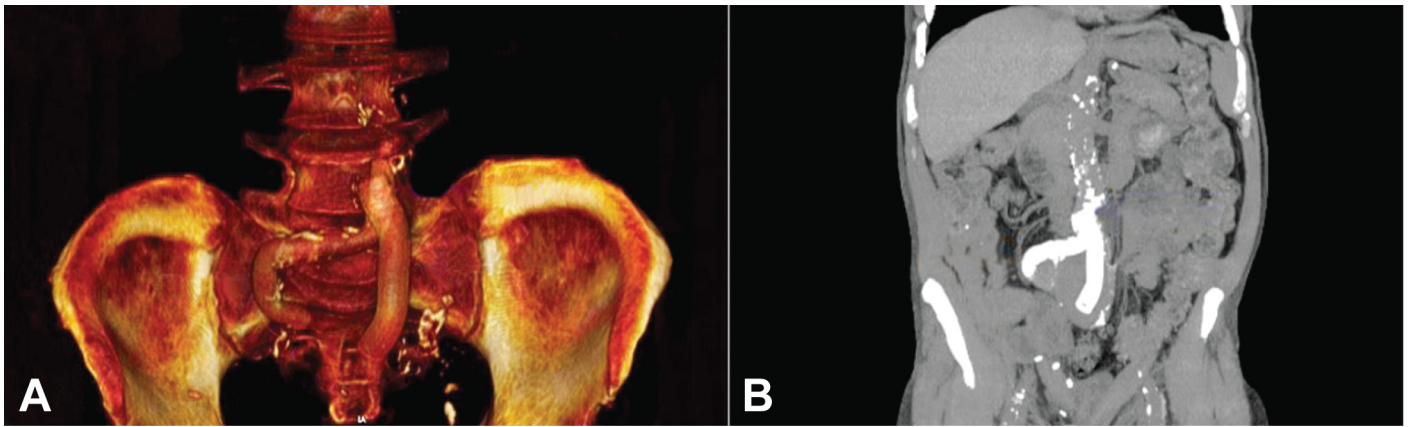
Computed tomography of the abdomen performed three months after the procedure. A - 3D reformation; and B - coronal plane; patency of the endoprosthesis in the iliac arteries position.
